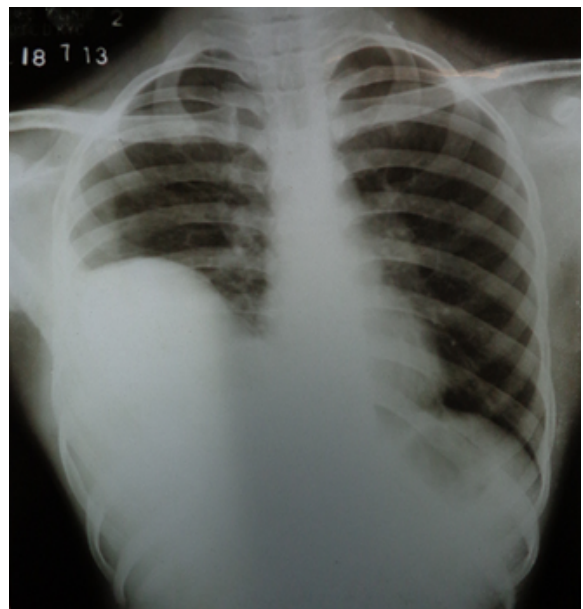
X-ray chest showing homogenous opacity in right lower zone
